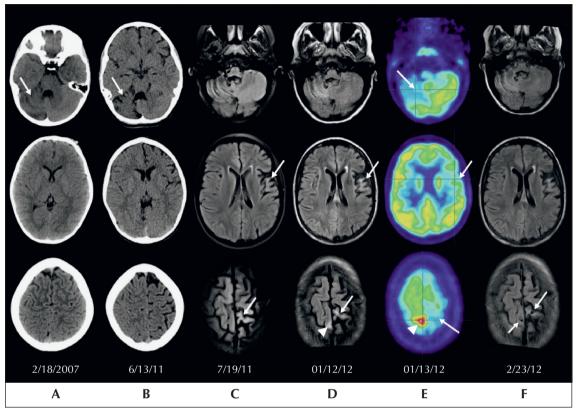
A) Initial CT scan obtained in 2007 (over four years prior to seizure onset). Note moderate right cerebellar volume loss (arrow). No other abnormality was identified. There was no evidence of left hemispheric volume loss. B) Head CT obtained at seizure onset in June 2011 demonstrated right cerebellar volume loss, which progressed slightly relative to the previous CT examination (arrow). Volume loss in the left cerebral hemisphere was identified, predominantly involving the frontal and anterior parietal lobe near the vertex. C) MRI obtained one month later (axial T2 FLAIR) demonstrated left hemispheric volume loss, right cerebellar volume loss, and increased signal consistent with gliosis (arrowhead), and regions of increased signal in the left hemispheric cortex and subjacent white matter (arrows). The right cerebral hemisphere was normal. D) MRI obtained with worsening daily seizures involving the left arm and leg (axial T2 FLAIR). New signal abnormality was noted in the right posterior frontal lobe involving the medial precentral gyrus and paracentral lobule (arrowhead). Persistent signal abnormalities were noted in the left hemisphere (arrows). Right cerebellum volume loss and signal were stable. E) FDG-PET performed the next day, with continued seizures, demonstrated a region of localised hypermetabolism (arrowhead) in the right posterior medial frontal lobe corresponding to the signal abnormality in (D). Regions of moderate to marked hypometabolism were noted in the left hemisphere and right cerebellum (arrows). F) MRI obtained after bilateral frontal biopsies, plasmapheresis, rituximab, and steroids (axial T2 FLAIR). Biopsy sites were identified in areas of previously noted signal abnormalities in the posterior frontal lobes at the vertex (arrows). Signal abnormality on the right decreased. Other areas of left hemispheric signal and right cerebellar volume loss were stable.
